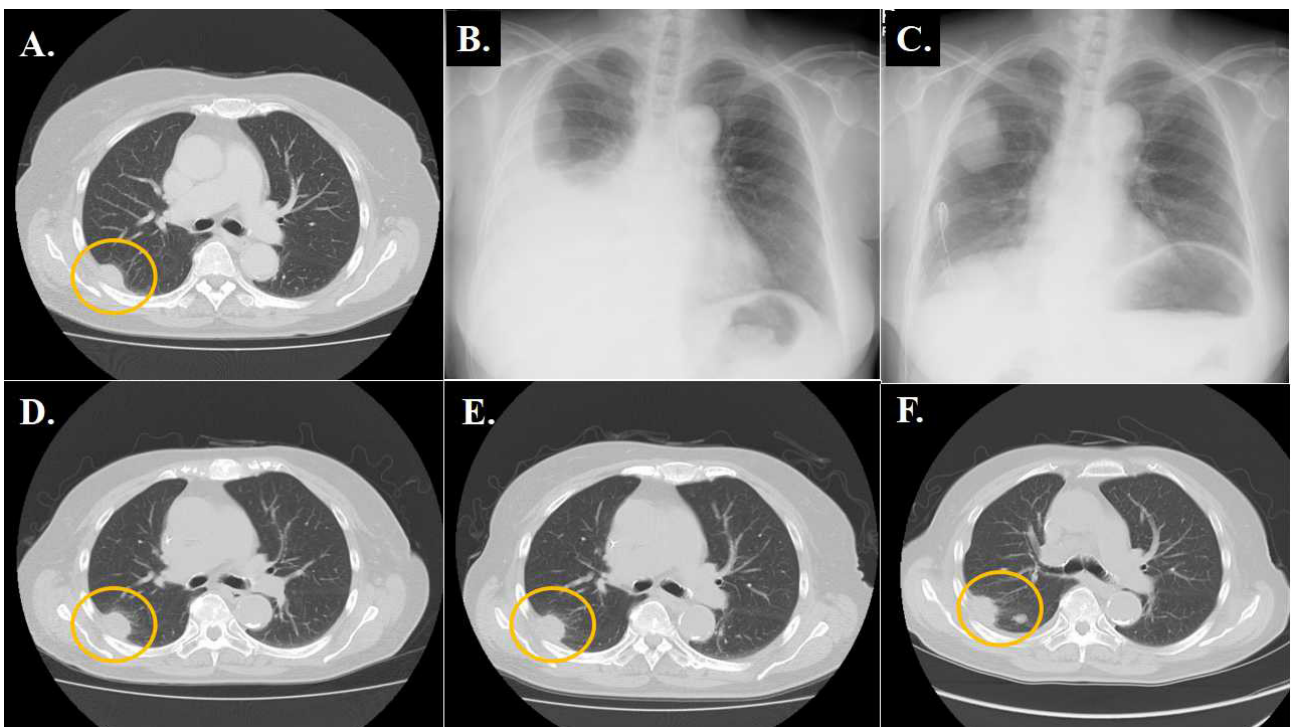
(A) Follow-up CT scan 24 months after surgery revealed new lung metastasis in his right lung. (B,C) Massive right pleural effusion was observed 7 months later, and the chest drainage and intrathoracic administration of CDDP were performed (2B: before drainage, 2C: after drainage). (D-F) Pleural effusion was not observed and disease control in the state of SD was achieved over a long period of 5 years (2D: at the age of 85 years, 2E: 86 years, 2F: 88 years).
